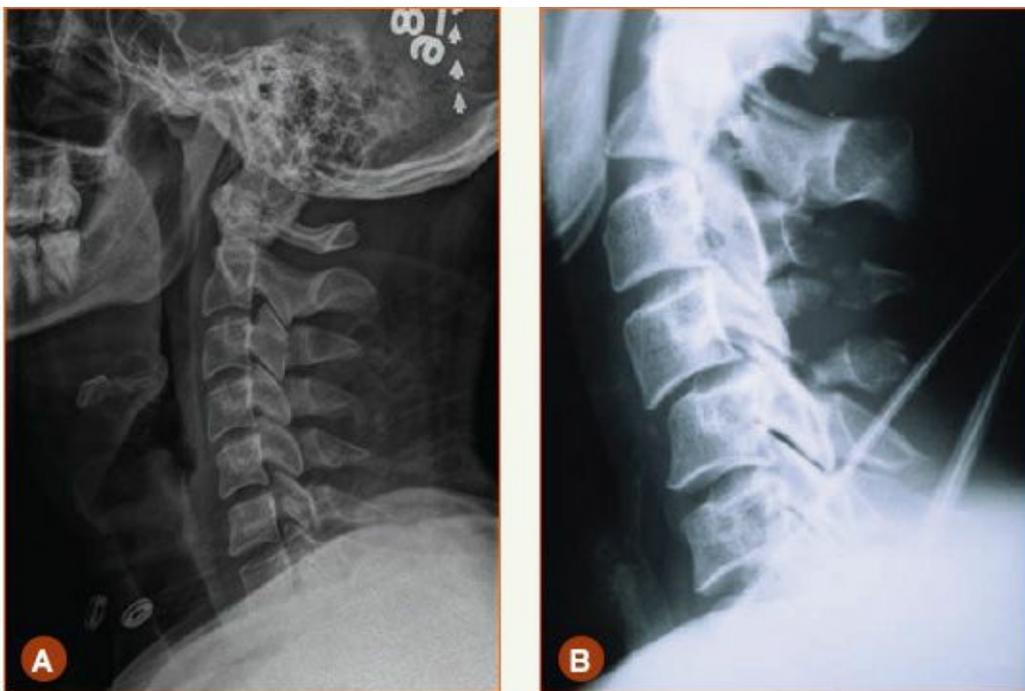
A. Normal cervical radiograph. B. Abnormal cervical radiograph.
